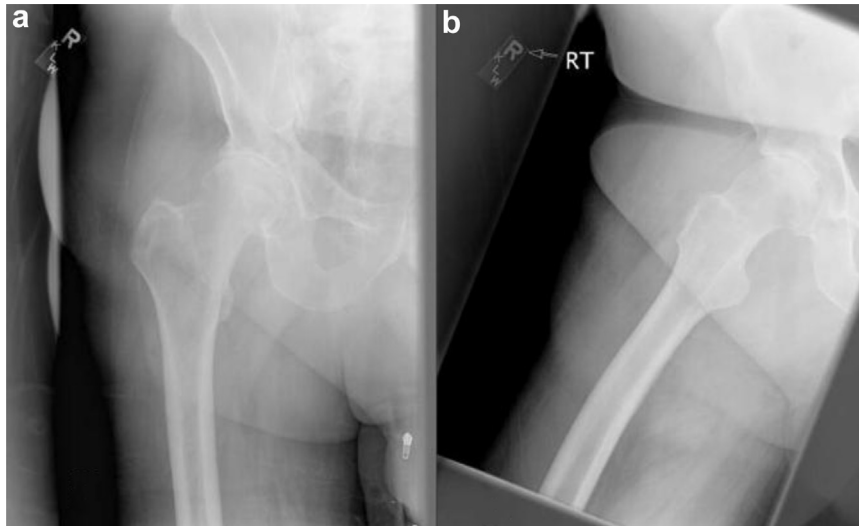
Preoperative anteroposterior (a) and frog leg lateral (b) radiographs of the right hip from September 2008 demonstrating severe osteoarthritis of the right hip.
